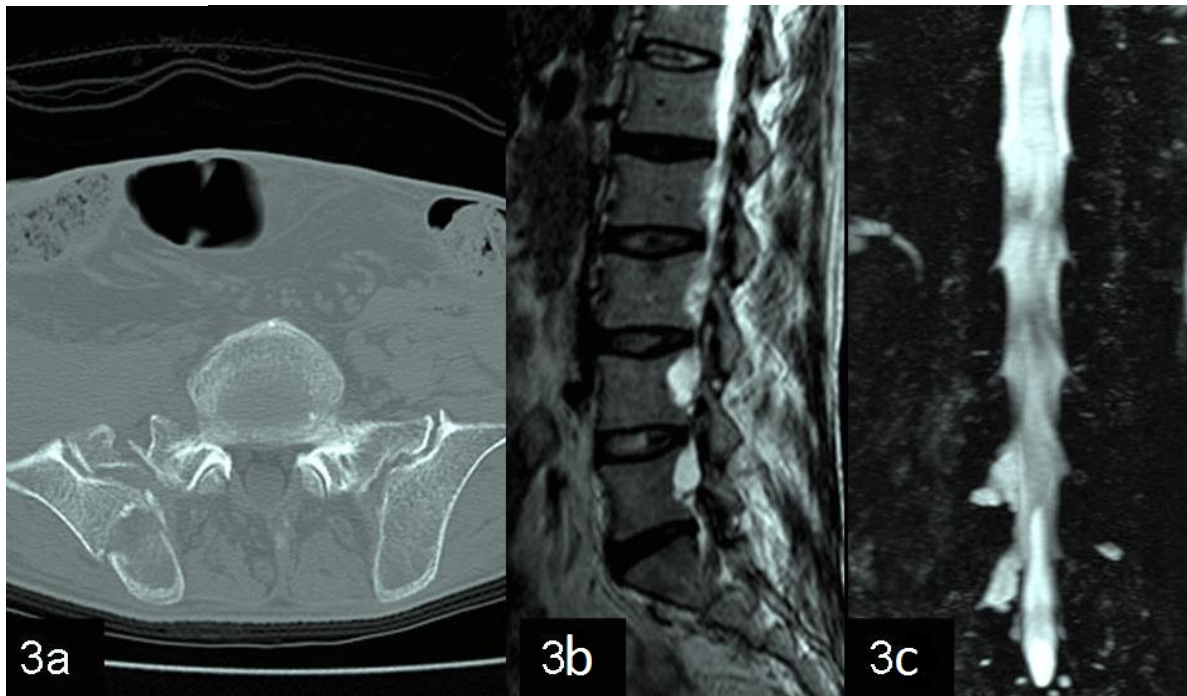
a-c: 3a. Axial CT scan and 3b-c. Coronal T2-weighted fast spin-echo MRI and MR myelography. 3a. Right iliac and sacral fractures. 3b. Scalloping posterior vertebral body contour due to pseudomeningocele. 3c. MR myelography images of pseudomeningocele.
